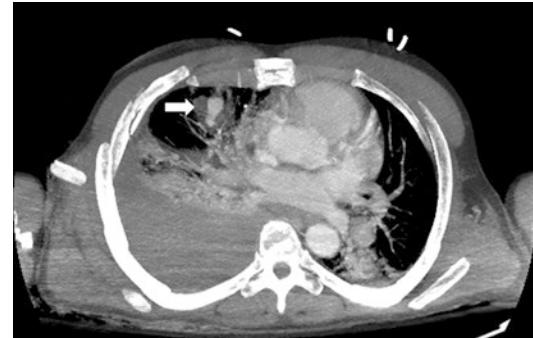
Forty eight-year-old man presenting with a stab wound. Maximum intensity projection (MIP) reconstruction image from CT angiography demonstrates a right mid-lung anterior pulmonary artery pseudoaneurysm (arrow)
